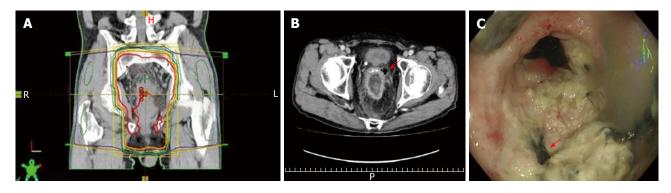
Rectal tumor perforation suggestive of chemoradiationdamage. Radiotherapy was delivered to the whole pelvis through three (one posterior-anterior and two lateral) or four (one anterior-posterior, one posterior-anterior and two lateral) fields using a 10-MV linear accelerator in the prone position (A); Coronal computed tomography findings showed a small bubble of extra-luminal gas (red arrow) (B); Preoperative colonoscopicfindings for radical surgery showed excavation with mucosa necrosis (red arrow) suggestive of chemoradiationdamage in the rectal tumor (C).
